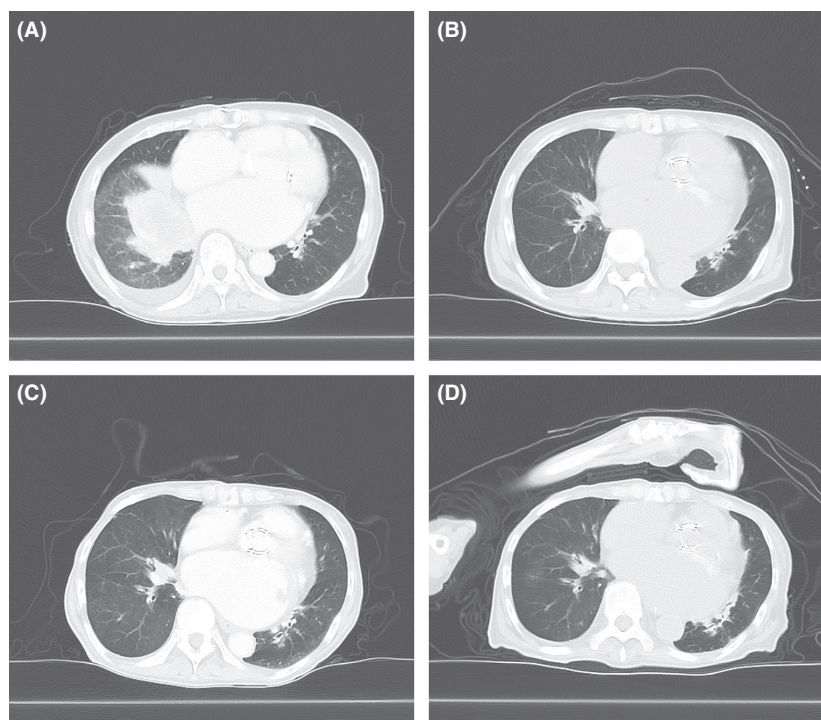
Computed tomography (CT) images of the right lower lobe of the lung. A and B show CT images obtained at 5 days before initiation of crizotinib and 1 month before discontinuation, respectively. C and D show CT images obtained at 2 weeks before and 6 months after initiation of alectinib, respectively.
